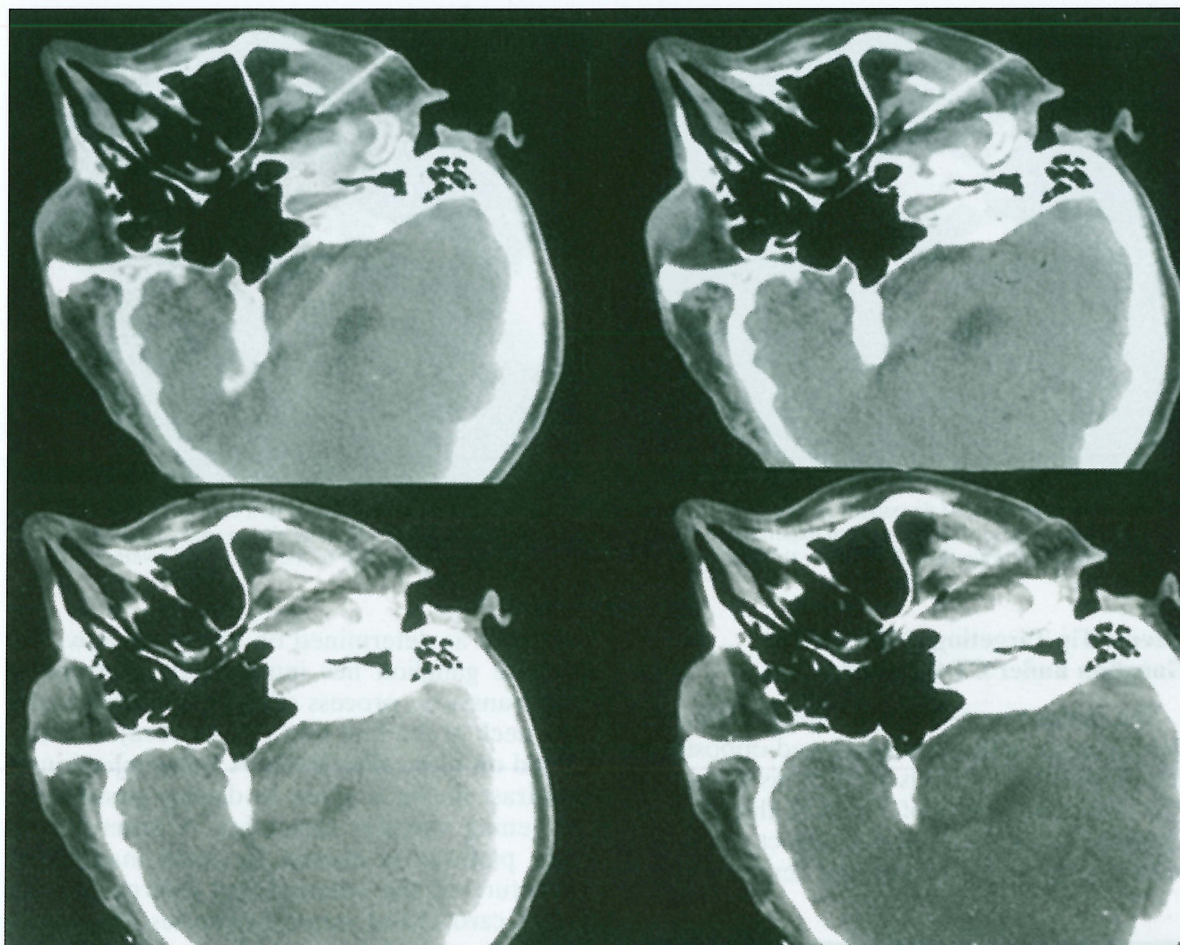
RF neurolysis in a patient with cluster headache. Needle is placed under step by step CT guidance (at target within the pterygopalatine fossa).
